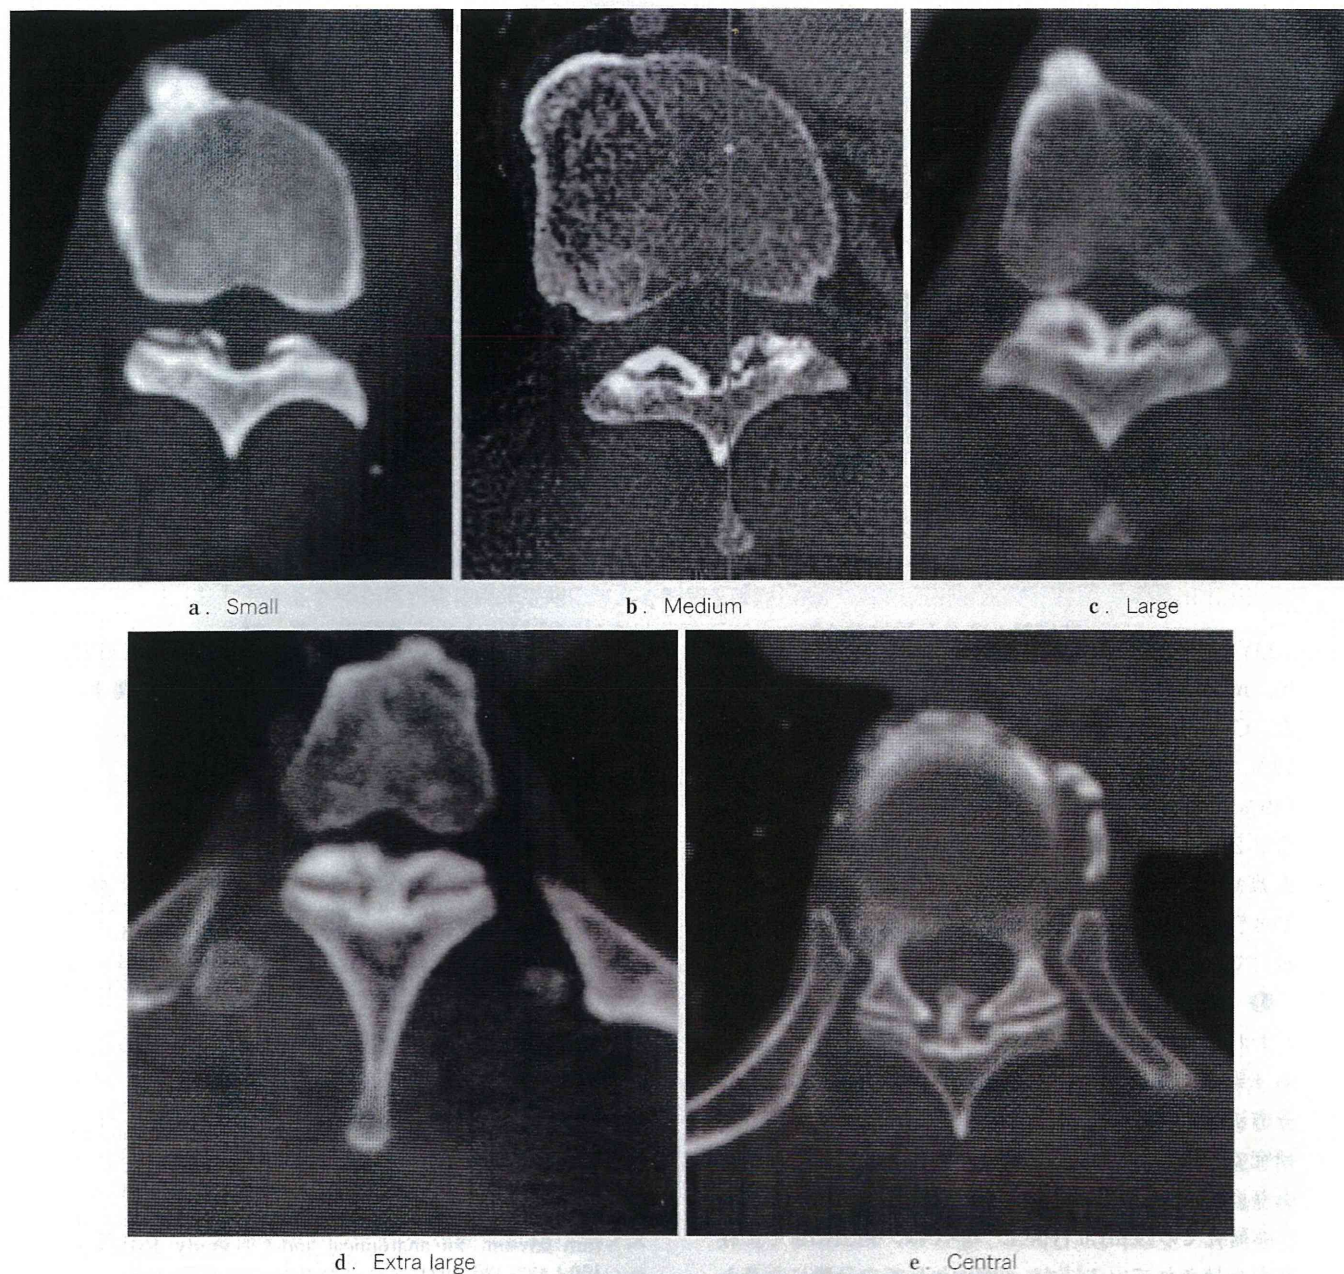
CT 水平断における胸椎黄色靭帯骨化症の分類 (文献 1 より転載)
